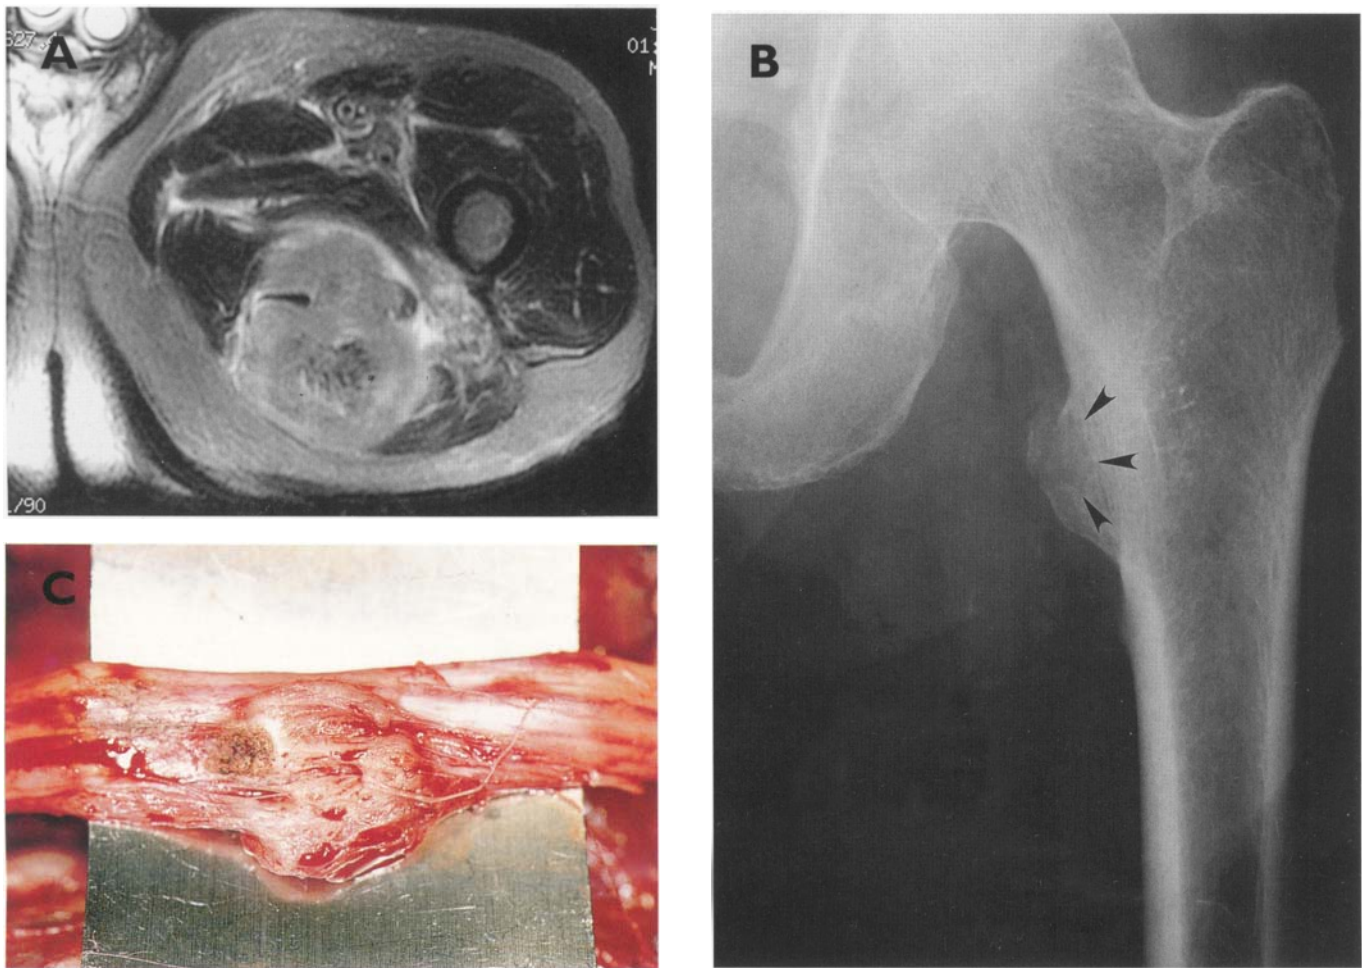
(A) Axial MRI, showing metastatic bladder carcinoma to the posterior thigh. (B) Plain radiograph of the proximal femur revealed direct invasion through the cortical bone with a pathological fracture of the lesser trochanter (arrows). (C) In surgery, exploration of the sciatic nerve revealed direct tumor involvement with extension under the epineurial sheath.
